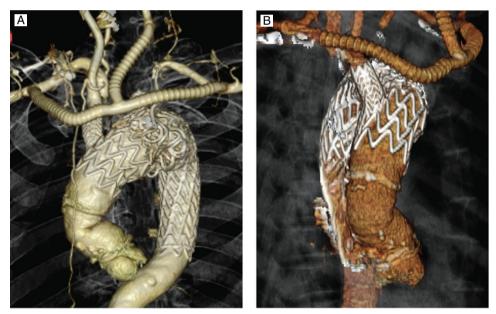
CT scan at 1 year after open conversion. The proximal stent of the main endograft with the chimney graft was tapered for anastomosis to the Dacron graft, probably preventing the occurrence of type 1a endoleak. (A and B) Three-dimensional images vary in an angle. CT: computed tomography
